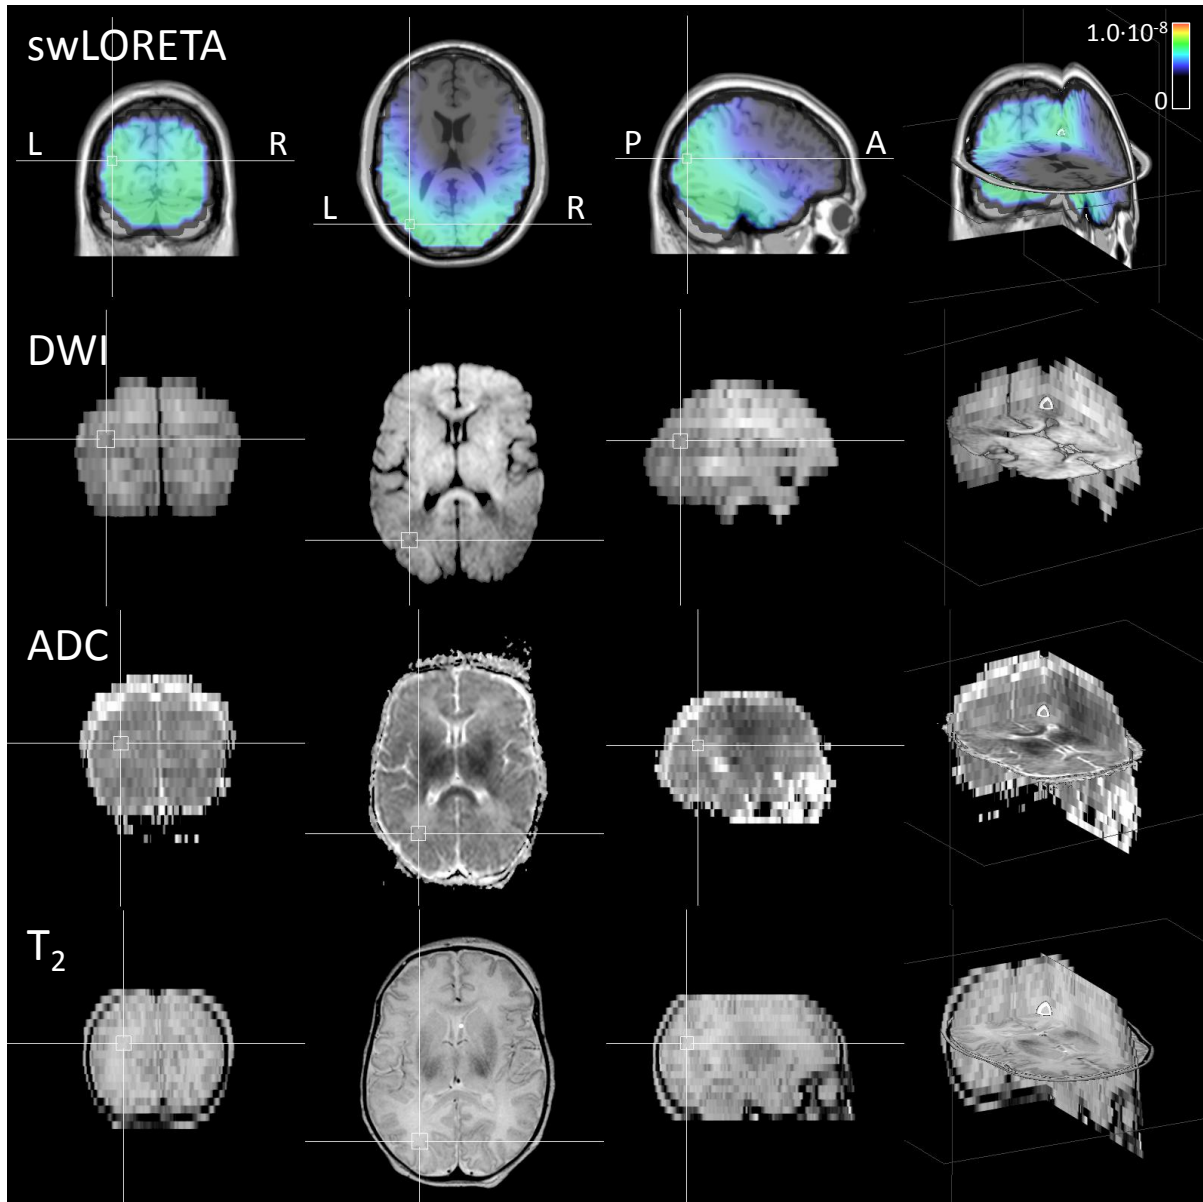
MRI images of patient 1 (DWI, ADC, T_2) displayed together with the swLORETA source localization. The color bar represents the current density probability, with red indicating a high probability for a current density hotspot. The inverse solution indicates that most EEG activity is situated in parietal, temporal and occipital lobes.
